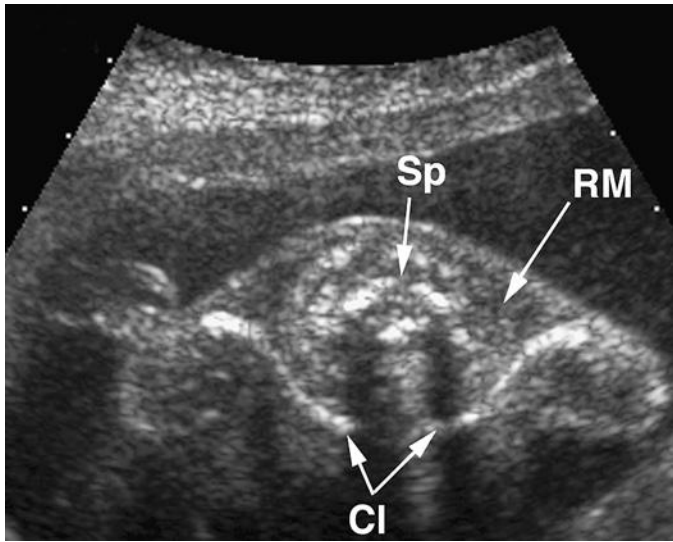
Axial sonogram of the clavicles (CI). RM, rhomboid muscle; Sp, spine.
